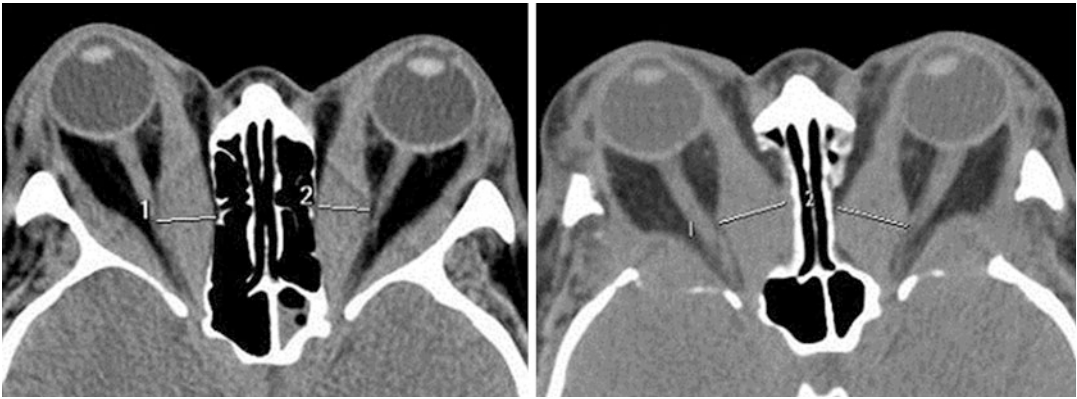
Preoperative and postoperative CT scans showing results of bilateral posterior orbital decompressions for thyroid eye disease characterized in part by bilateral optic neuropathy. Note expansion of the medial rectus
